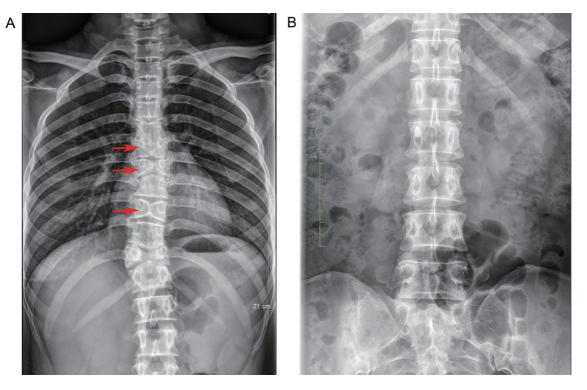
Butterfly vertebrae in the thoracic and upper lumbar regions. X-ray images of (A) case 2 showing butterfly vertebrae (red arrows) and (B) of normal control.
